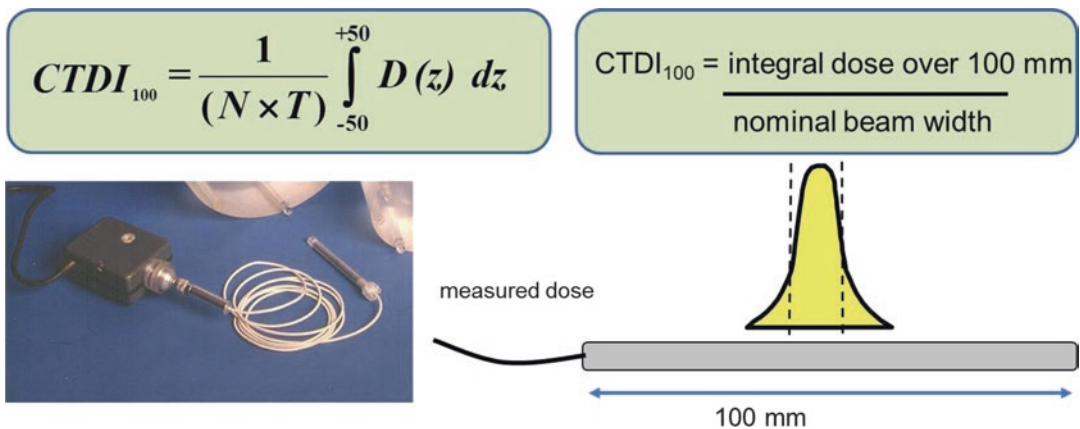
The CTDI equation and presentation of an easy approach to remember it. $D(z)$ is the single-slice dose profile, N is the number of image slices of thickness (T) that are acquired simultaneously and $(N \times T)$ is usually equivalent to the nominal beam width. Also shown are the CT
